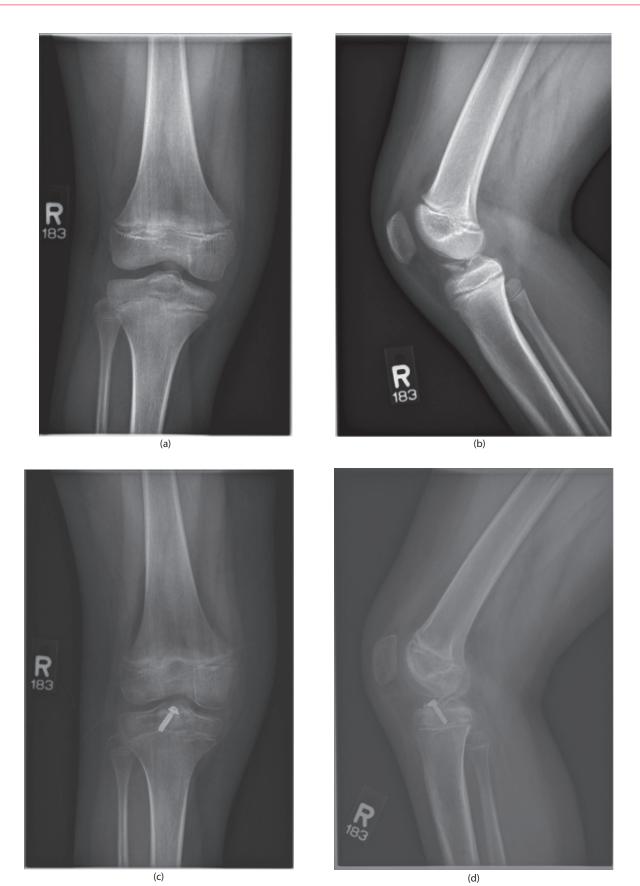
(a) and (b) Radiographs of an 8-year-old female with a type 3 tibial spine fracture. (c) and (d) The fracture was treated with arthroscopic suture and screw fixation within the epiphysis to avoid injury to the proximal tibial physis. Radiographs show advanced healing at 4 months postoperatively.
